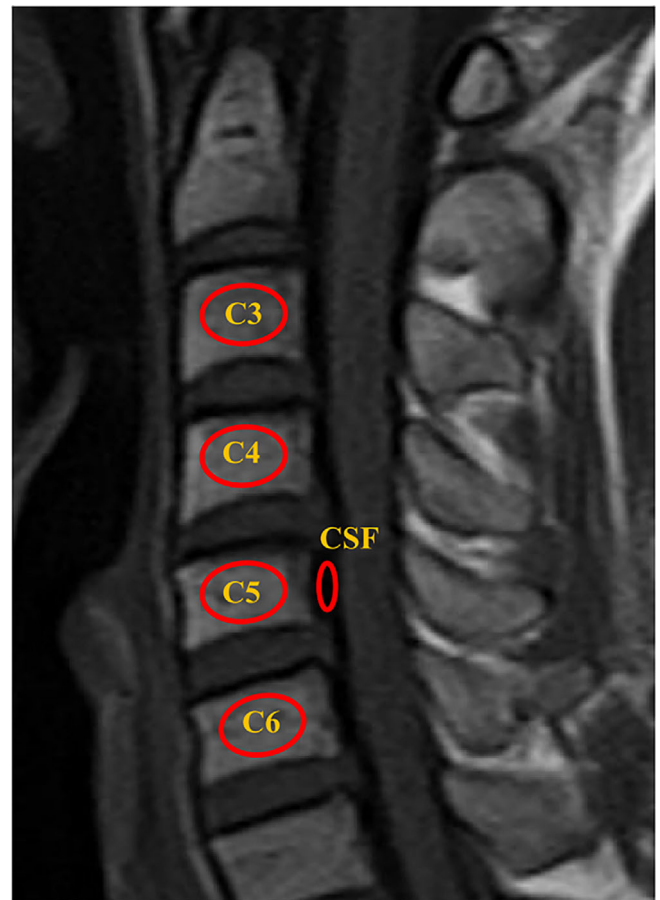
An example of a signal intensity measurement for the vertebral bone quality score based on sagittal non-contrast-enhanced T1-weighted magnetic resonance imaging of the cervical spine. CSF, cerebrospinal fluid.
